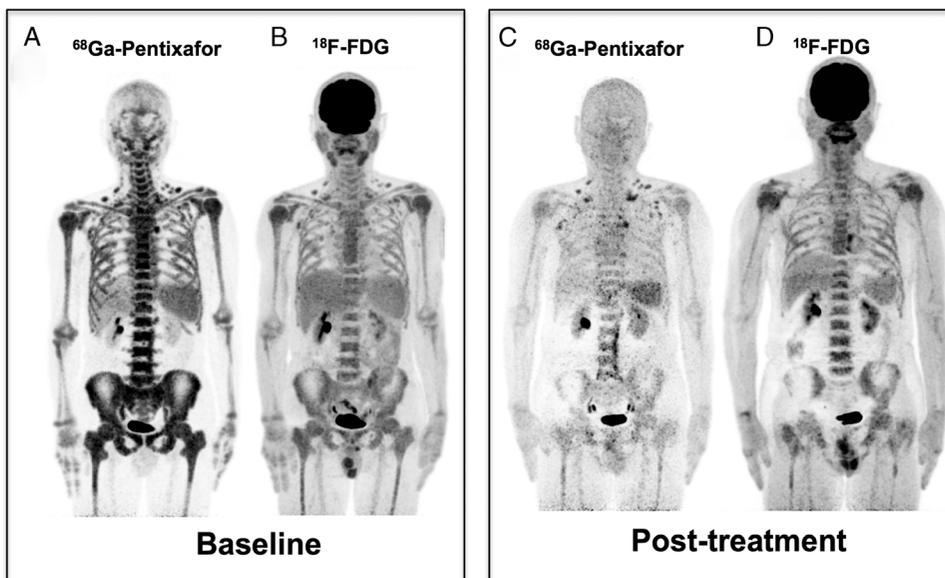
Patient 11 (male, 62 years, high risk of ISS-WM) with clinical VGPR after 4 cycles of chemotherapy with DRC. At baseline, ^{68}Ga -pentixafor (A) and ^{18}F -FDG (B) PET/CT detected diffuse bone marrow disease and multiple lymph node involvement, with more intense uptake of ^{68}Ga -pentixafor than the ^{18}F -FDG uptake in these lesions. After completion of chemotherapy, the follow-up ^{68}Ga -pentixafor PET/CT (C) showed markedly reduced uptake of ^{68}Ga -pentixafor in bone marrow and diminished lymph nodes. However, ^{18}F -FDG PET/CT at follow-up (D) did not detect significant change of the bone marrow uptake intensity (D, dexamethasone; R, rituximab; C, cyclophosphamide).
